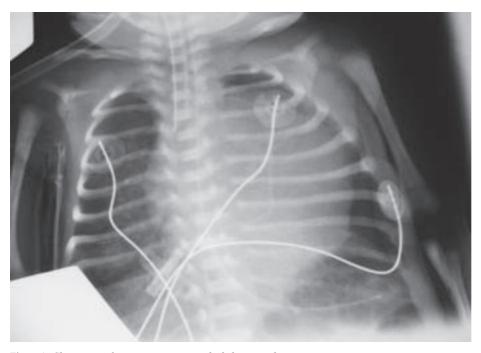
Chest x-ray of a preterm neonate with chylopericardium Slika 1. Rtg pluća nedonošćeta s hiloperikardom
